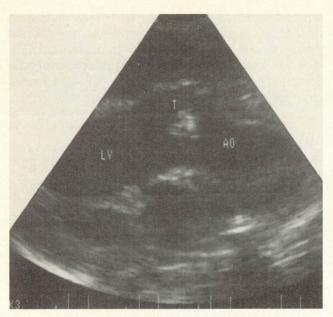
Two-dimensional echocardiography (parasternal long-axis view) demonstrates the aortico-ventricular tunnel (T) communicating between the aorta (Ao) and the left ventricular chamber (LV), separate from the posteriorly displaced aortic valve and aortic annulus.
